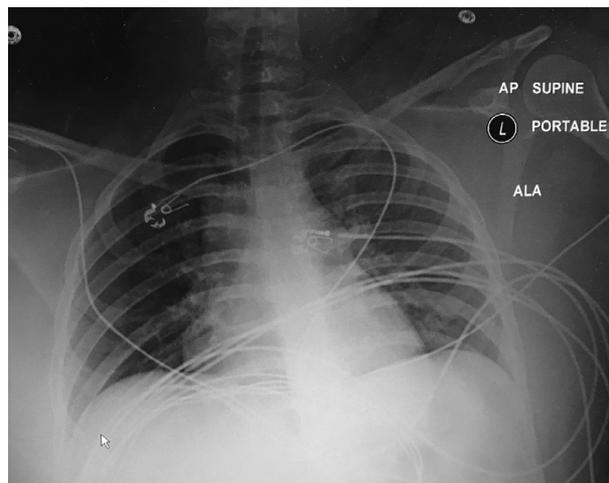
Chest x-ray in Emergency Room.
